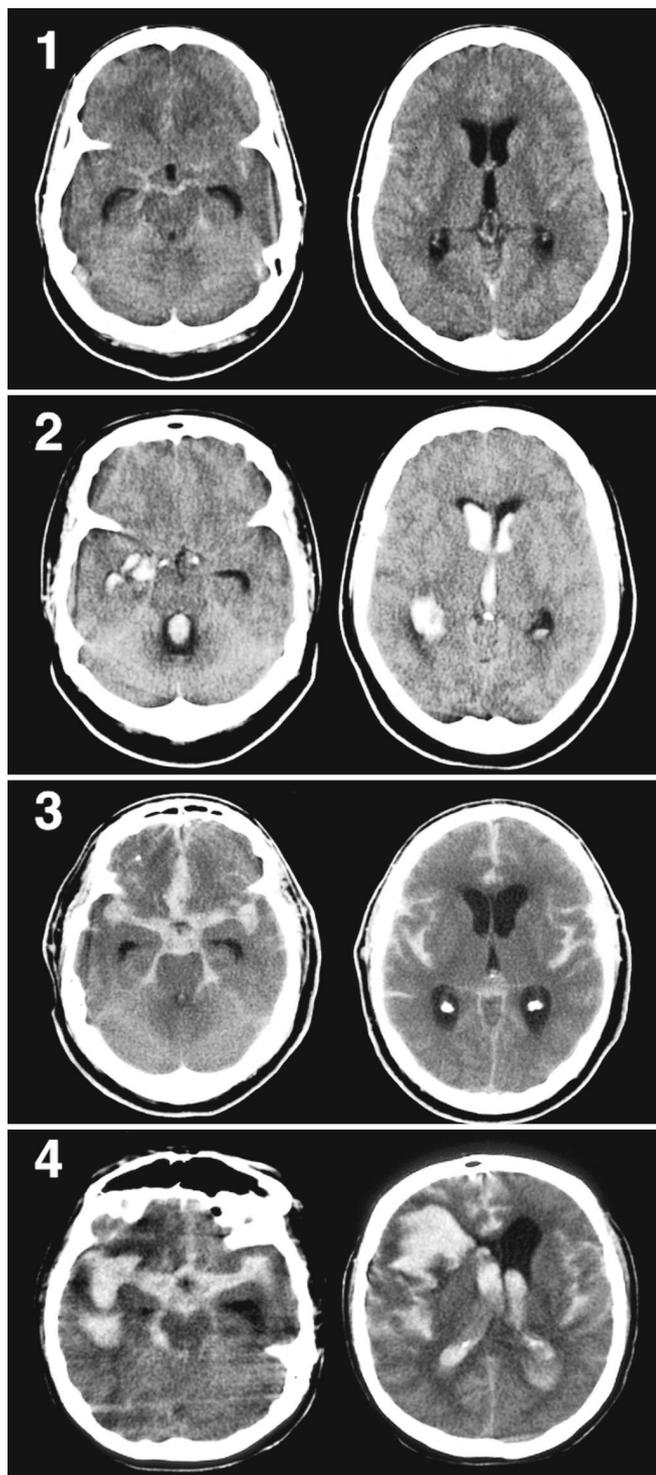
CT scans demonstrating the modified Fisher CT rating scale. Grade 1 (minimal or diffuse thin SAH without IVH), indicating low risk for symptomatic vasospasm; Grade 2 (minimal or thin SAH with IVH); Grade 3 (thick cisternal clot without IVH), indicating intermediate risk for symptomatic vasospasm; and Grade 4 (cisternal clot with IVH), indicating high risk for symptomatic vasospasm (from, [5]).
